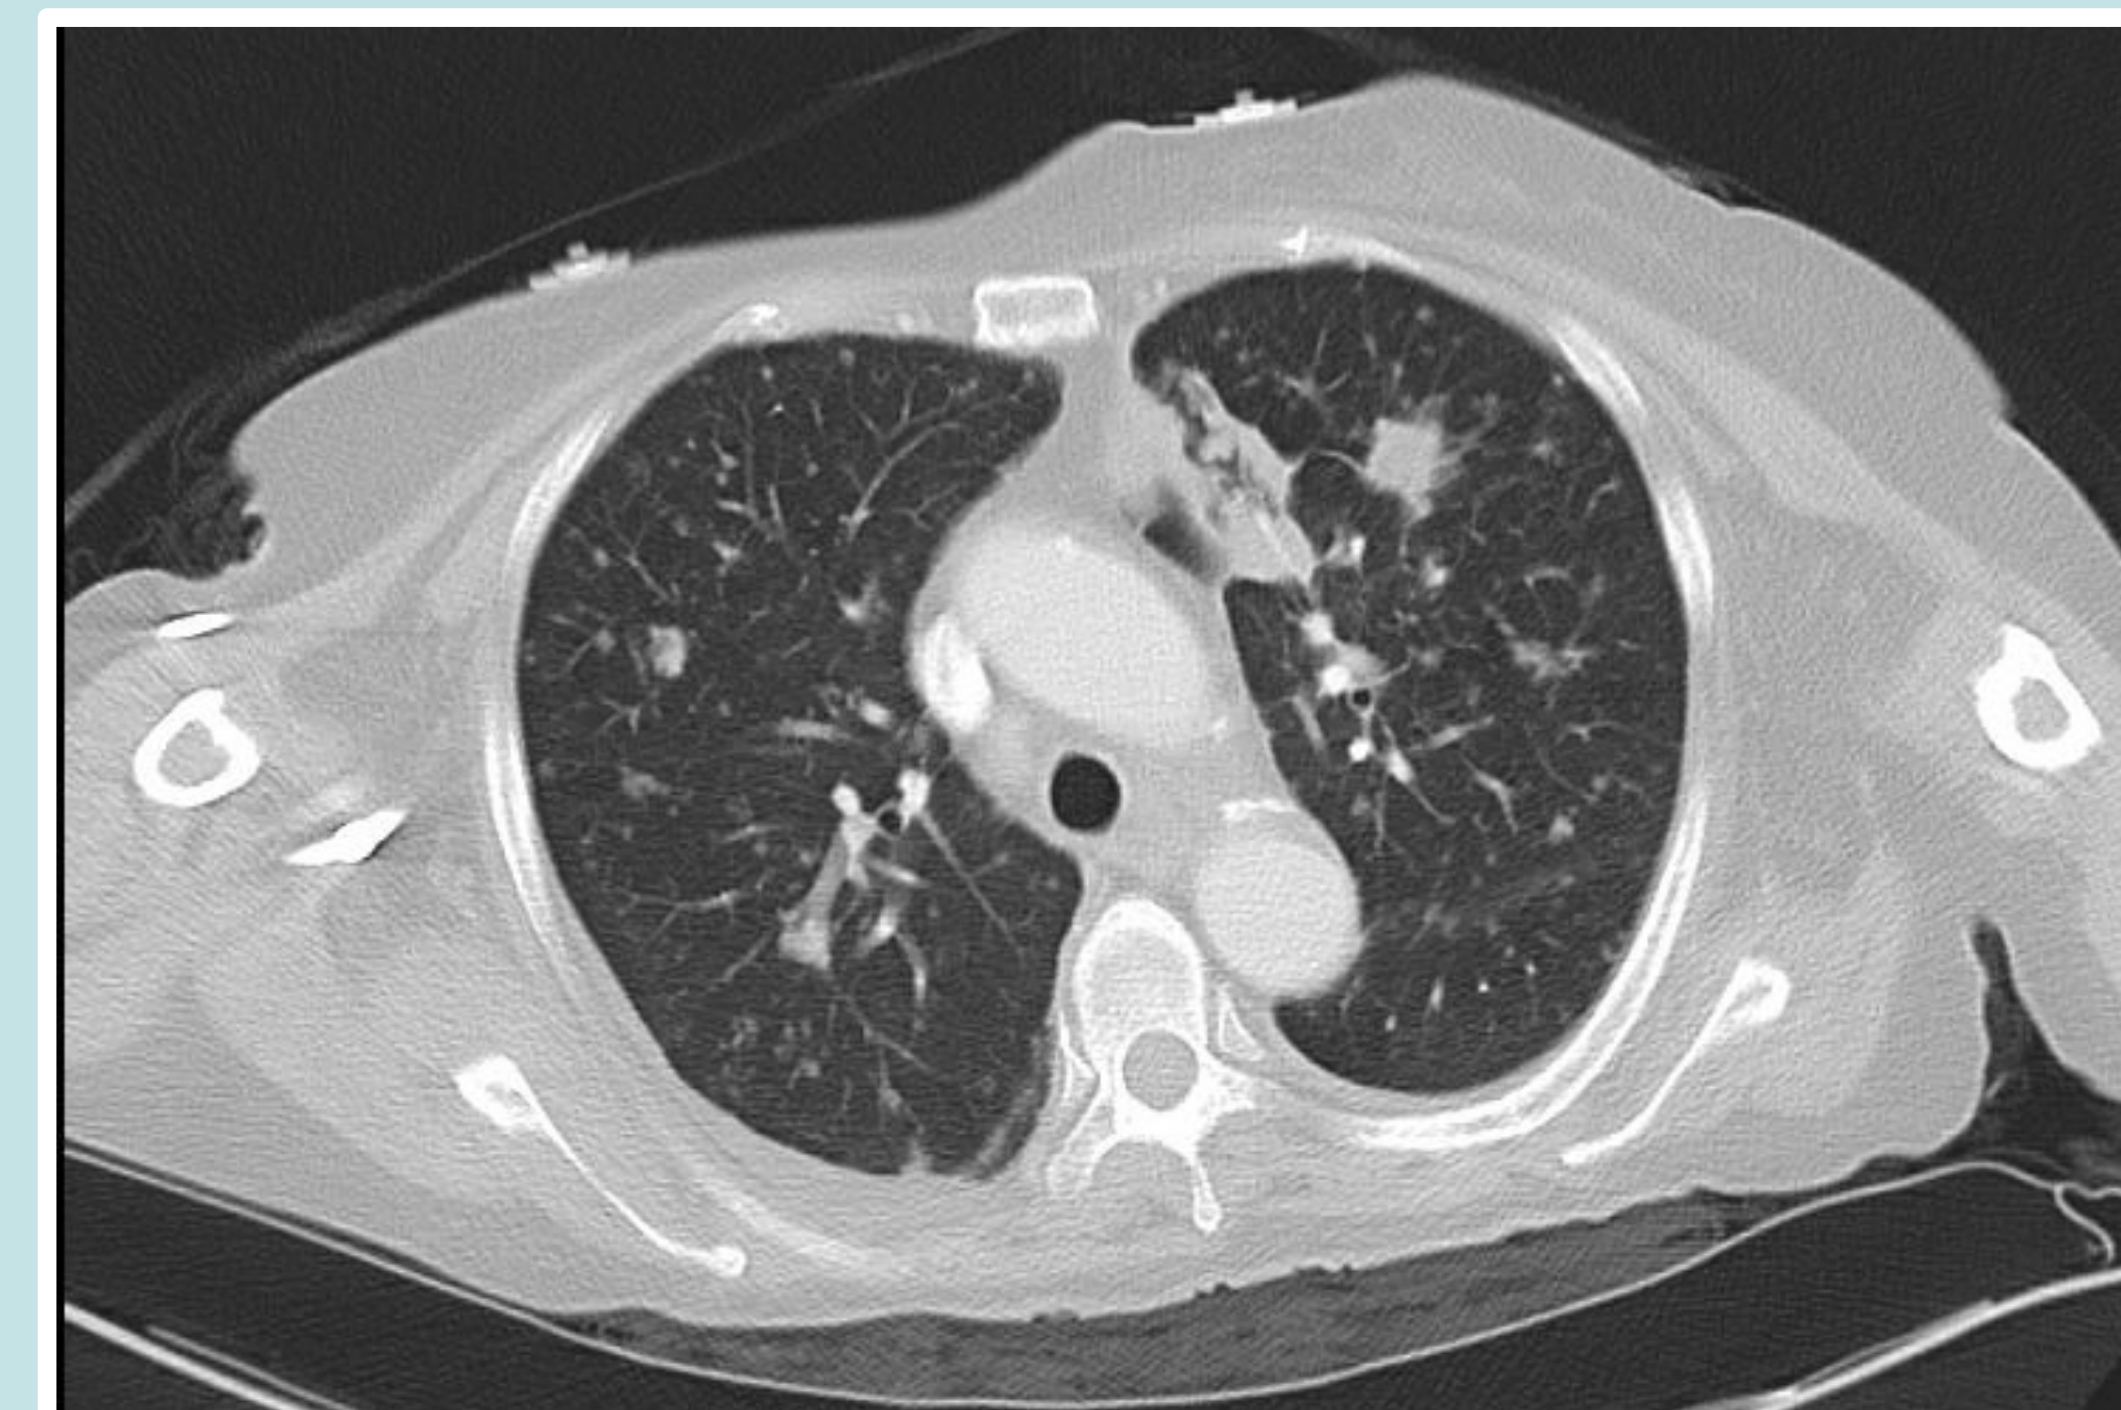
Axial CT chest with contrast demonstrating bilateral spiculated ground glass pulmonary opacities, pleural thickening/opacity of the left upper lobe pericardiac region and mediastinal lymphadenopathy.
